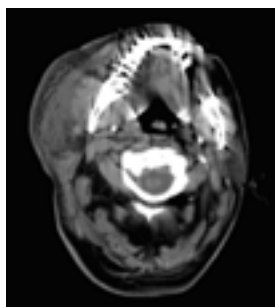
CT scan showing submandibular swelling and subcutaneous emphysema
